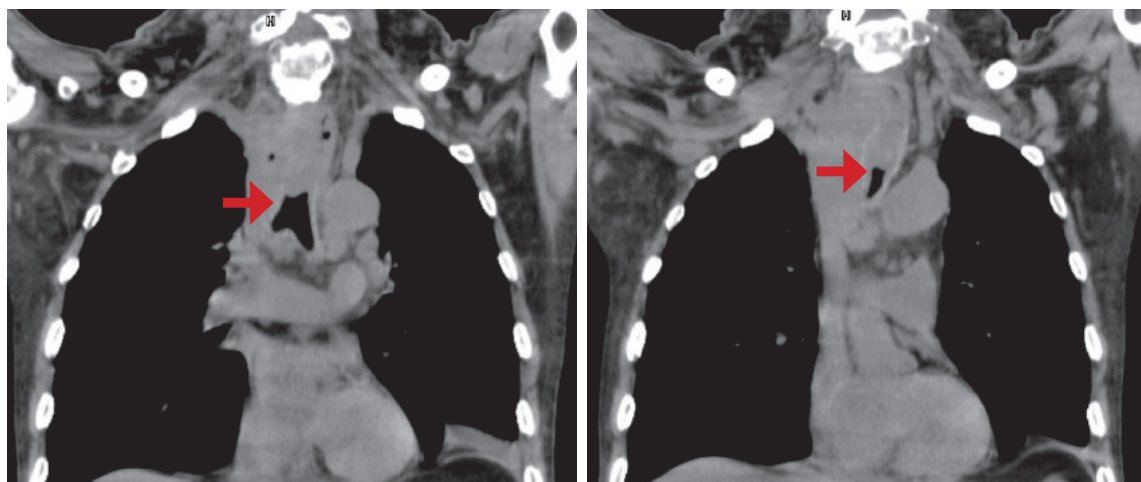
CT scan revealing a mass that invades the upper intrathoracic trachea
